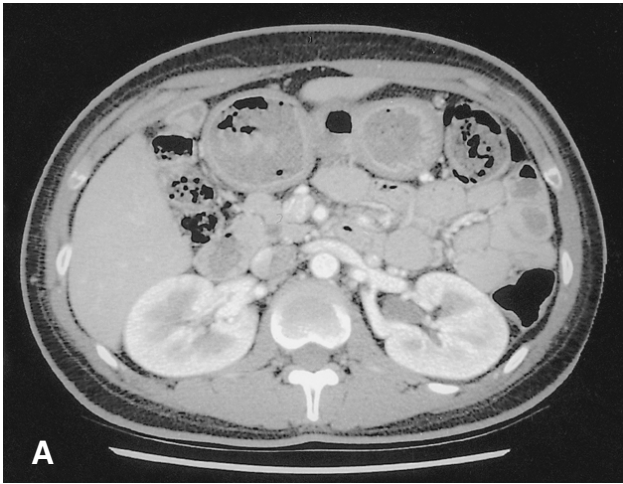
Abdominal computed tomography (CT) reveals a normal-appearing pancreatic head (A) and complete absence of the body and tail (B).
